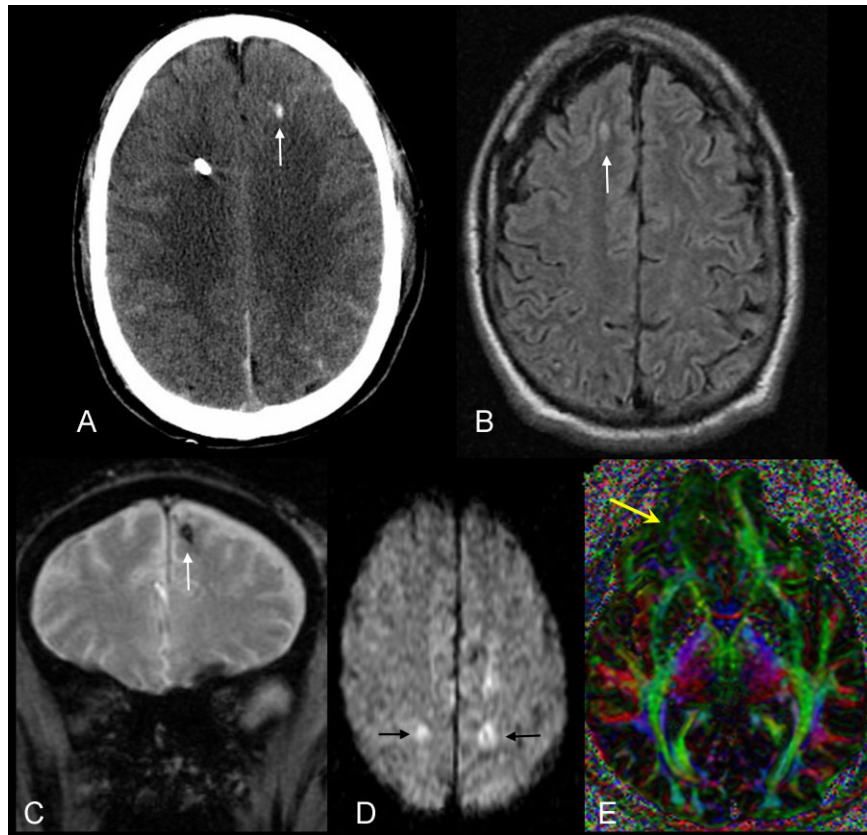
Diffuse axonal injury on computed tomography and magnetic resonance imaging. (A) The axial computed tomography image reveals a small hyperdense focus (arrow) at the gray-white junction of the left frontal lobe consistent with hemorrhagic diffuse axonal injury. Bilateral high attenuation with the sulci of the frontal and parietal lobes represents acute subarachnoid hemorrhage. The intensely dense focus with streak artifact within the right frontal lobe is from a ventricular drainage catheter. (B) The axial fluid attenuated inversion recovery image shows an additional lesion (arrow) within the peripheral gray-white junction of the right frontal lobe. (C) The coronal gradient-recalled-echo T2*-weighted image demonstrates a low signal focus (arrow) at the gray-white junction of the left superior frontal gyrus consistent with deoxyhemoglobin from hemorrhagic diffuse axonal injury. (D) The diffusion-weighted image shows reduced diffusion within the parietal lobe subcortical white matter bilaterally (arrows). (E) In a different patient with a history of moderate traumatic brain injury and diffuse axonal injury, the color fractional anisotropy map shows a reduction in fractional anisotropy in the white matter tract of the right inferior frontal lobe (arrow). [Color figure can be viewed in the online issue, which is available at www.interscience.wiley.com.]
